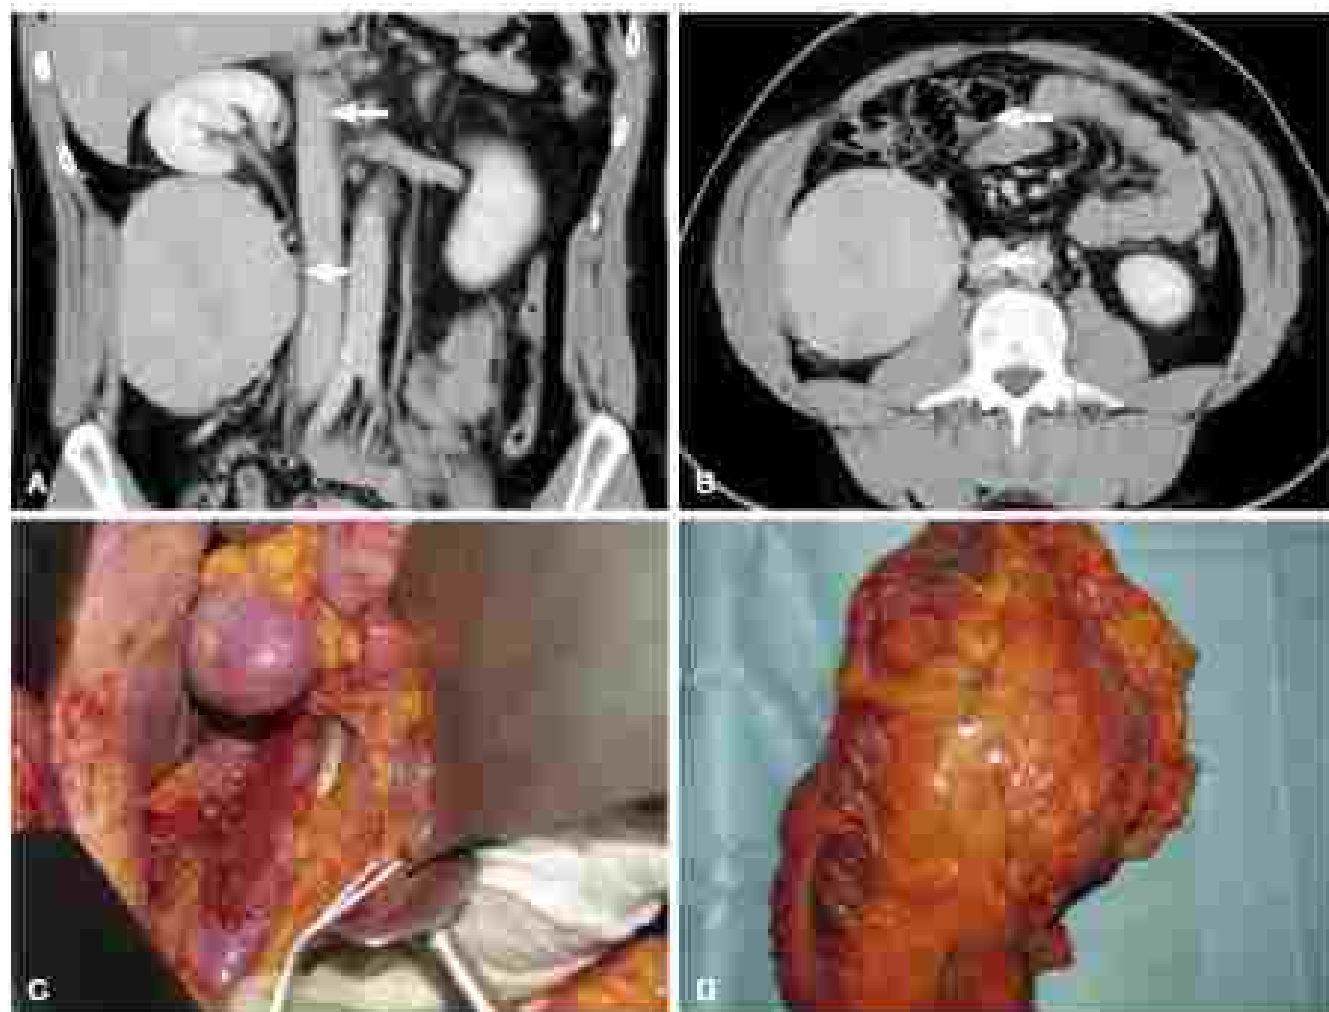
(A, B) Coronal and axial computed tomography images of a right retroperitoneal solitary fibrous tumor (short arrow) displacing the right kidney and the right colon (long arrow). Surgical field (C) after tumor removal in situ with preserved aorta, psoas muscle, back, and right colon (D).
